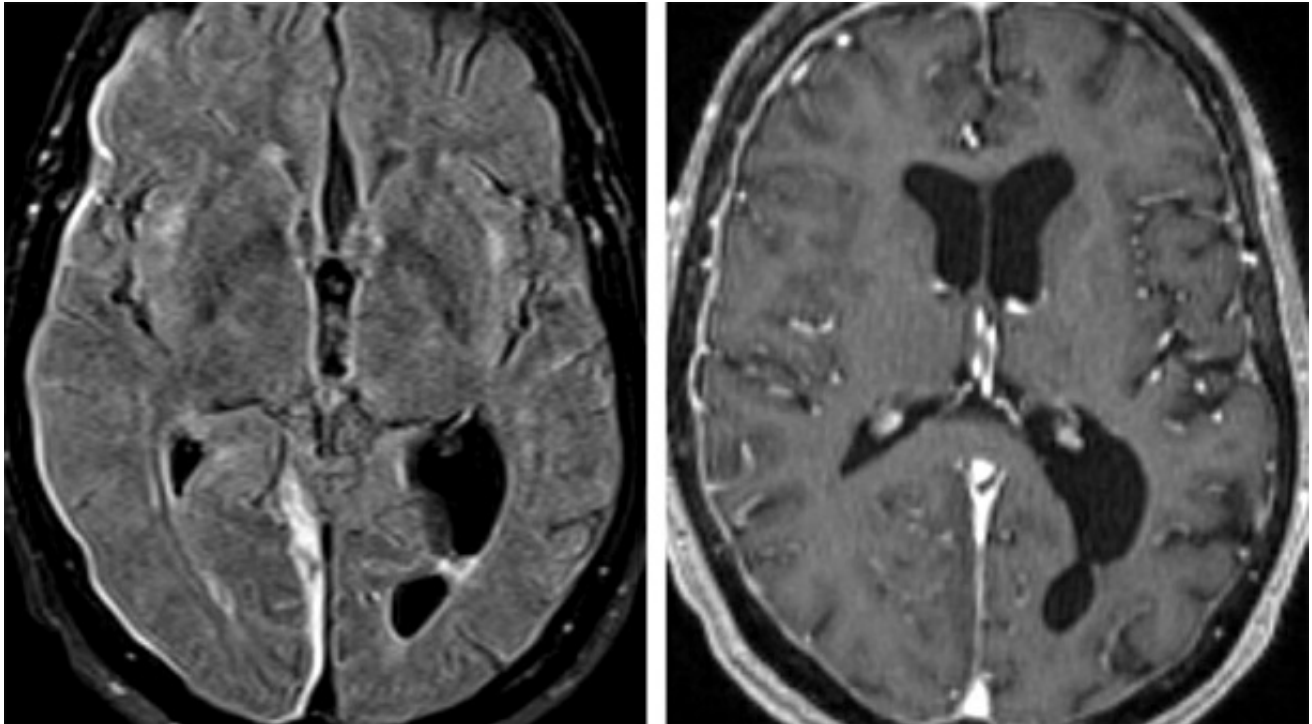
This thin FLAIR-hyperintense early chronic subdural hematoma (left) wraps around the right cerebral hemisphere. There is associated enhancement of the dura on contrast-enhanced T1 weighted image (right) that likely represents granulation tissue and hyperemia reactive to the hematoma.
